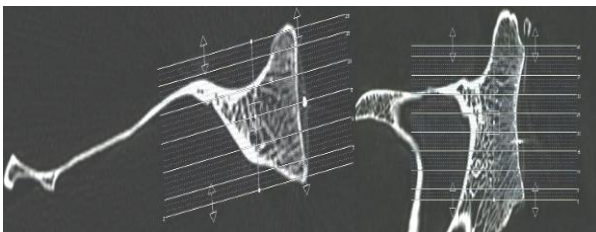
standardized method of CT scan scouts.
